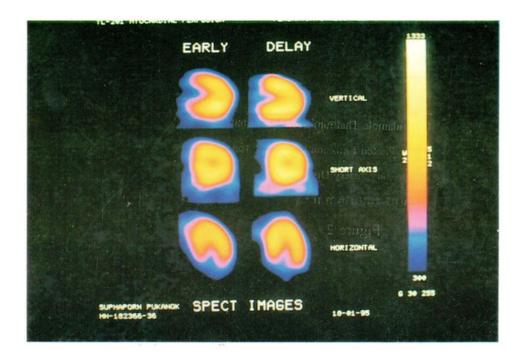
Dipyridamole stress and redistribution images of thallium-201 myocardial perfusion SPECT study in a patient with normal coronary arteriogram. There is homogeneous distribution of radioactivity in allof the myocardial walls.
